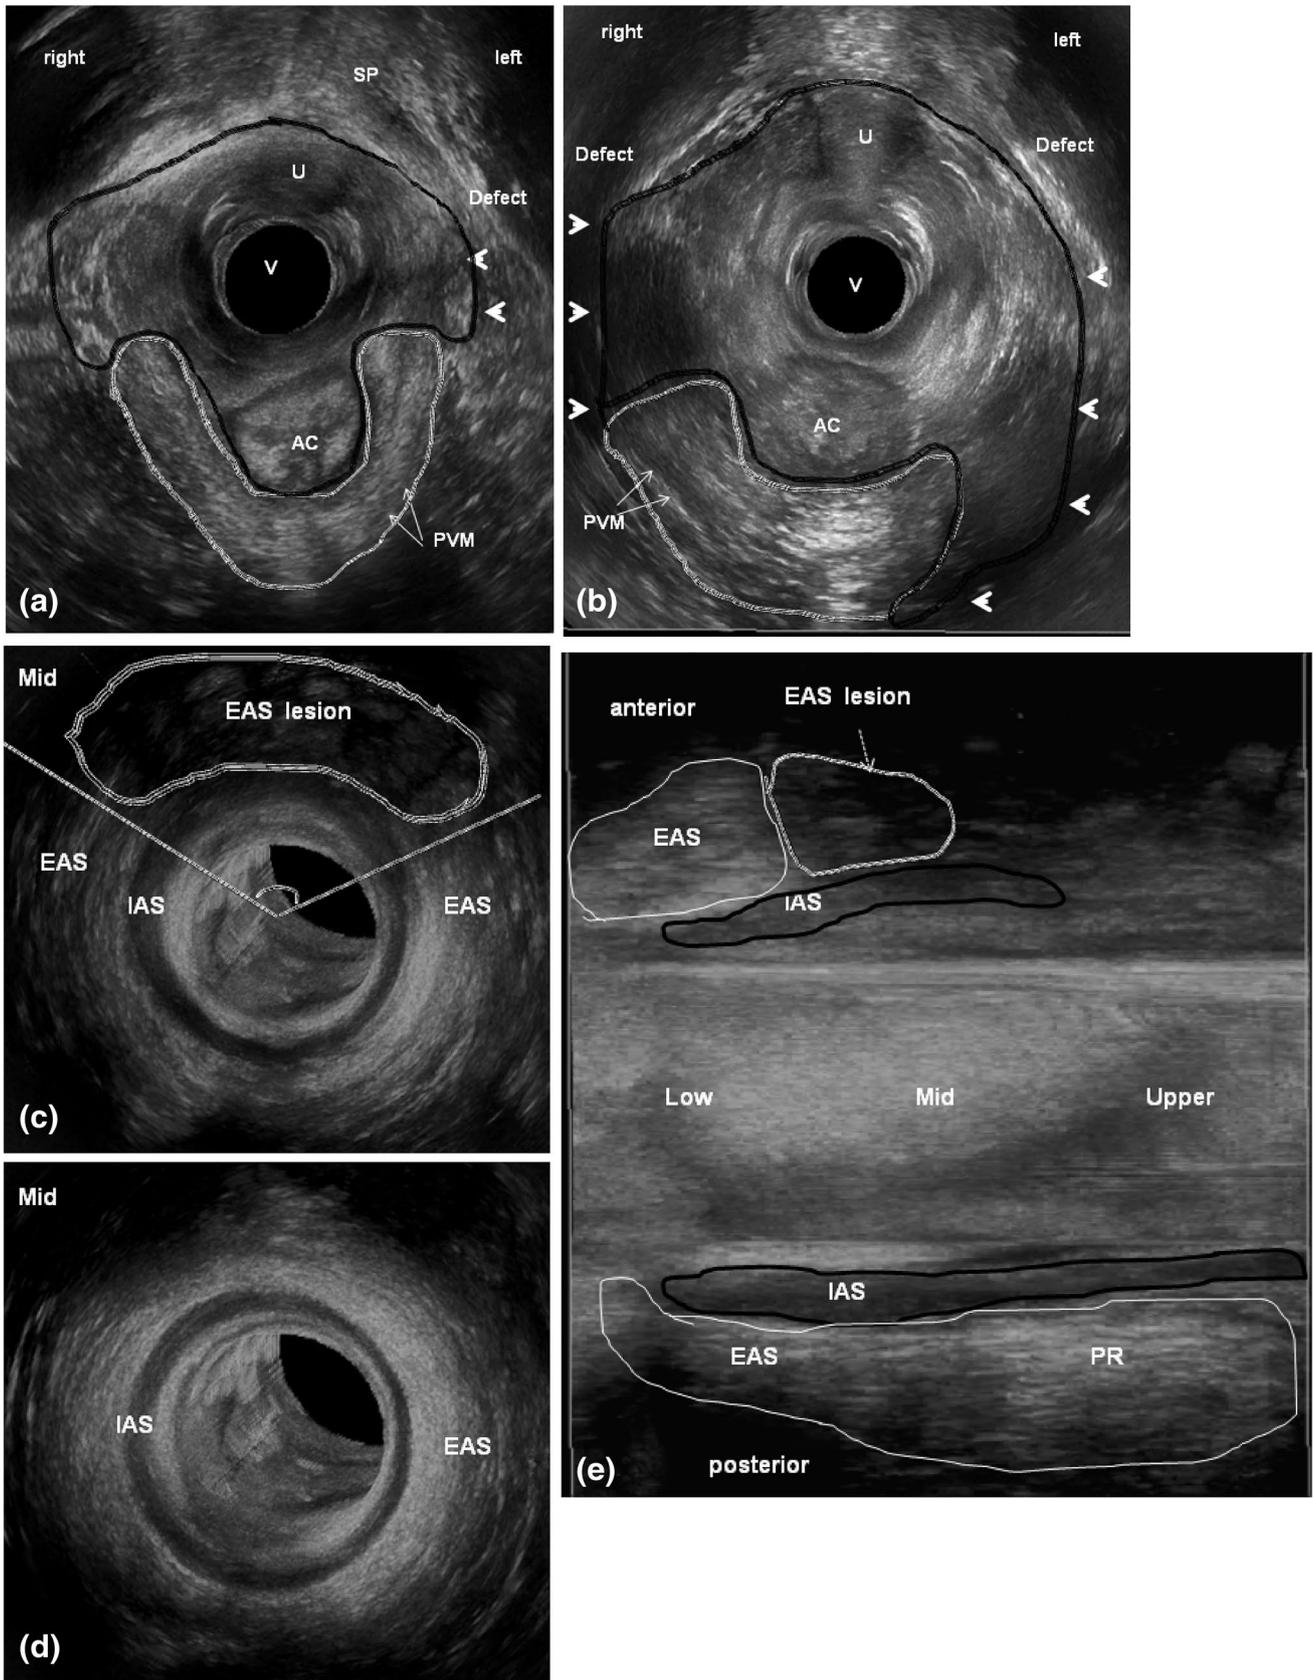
3D-ultrasound—patient with bilateral pubovisceral muscle defect and partial external anal sphincter defect after vaginal delivery (render-mode). a Endovaginal approach showing a bilateral pubovisceral muscle defect (arrows head) and area of the levator hiatus at rest (black drawn) (axial plane). b Endovaginal approach—increased area of the levator hiatus in the Valsalva maneuver (black drawn) (axial plane). c Anorectal approach showing an external anal sphincter muscle defect in the anterior quadrant and angle of the external anal sphincter defect in the mid anal canal (axial plane). d Anorectal approach showing intact sphincter muscles in the distal part of the mid anal canal (axial plane). e Anorectal approach showing external anal sphincter muscle defect and residual external anal sphincter length (sagittal plane). *U* urethra, *V* vagina, *AC* anal canal, *PMV* pubovisceral muscles, *EAS* external anal sphincter, *IAS* internal anal sphincter, *PR* puborectalis muscle
